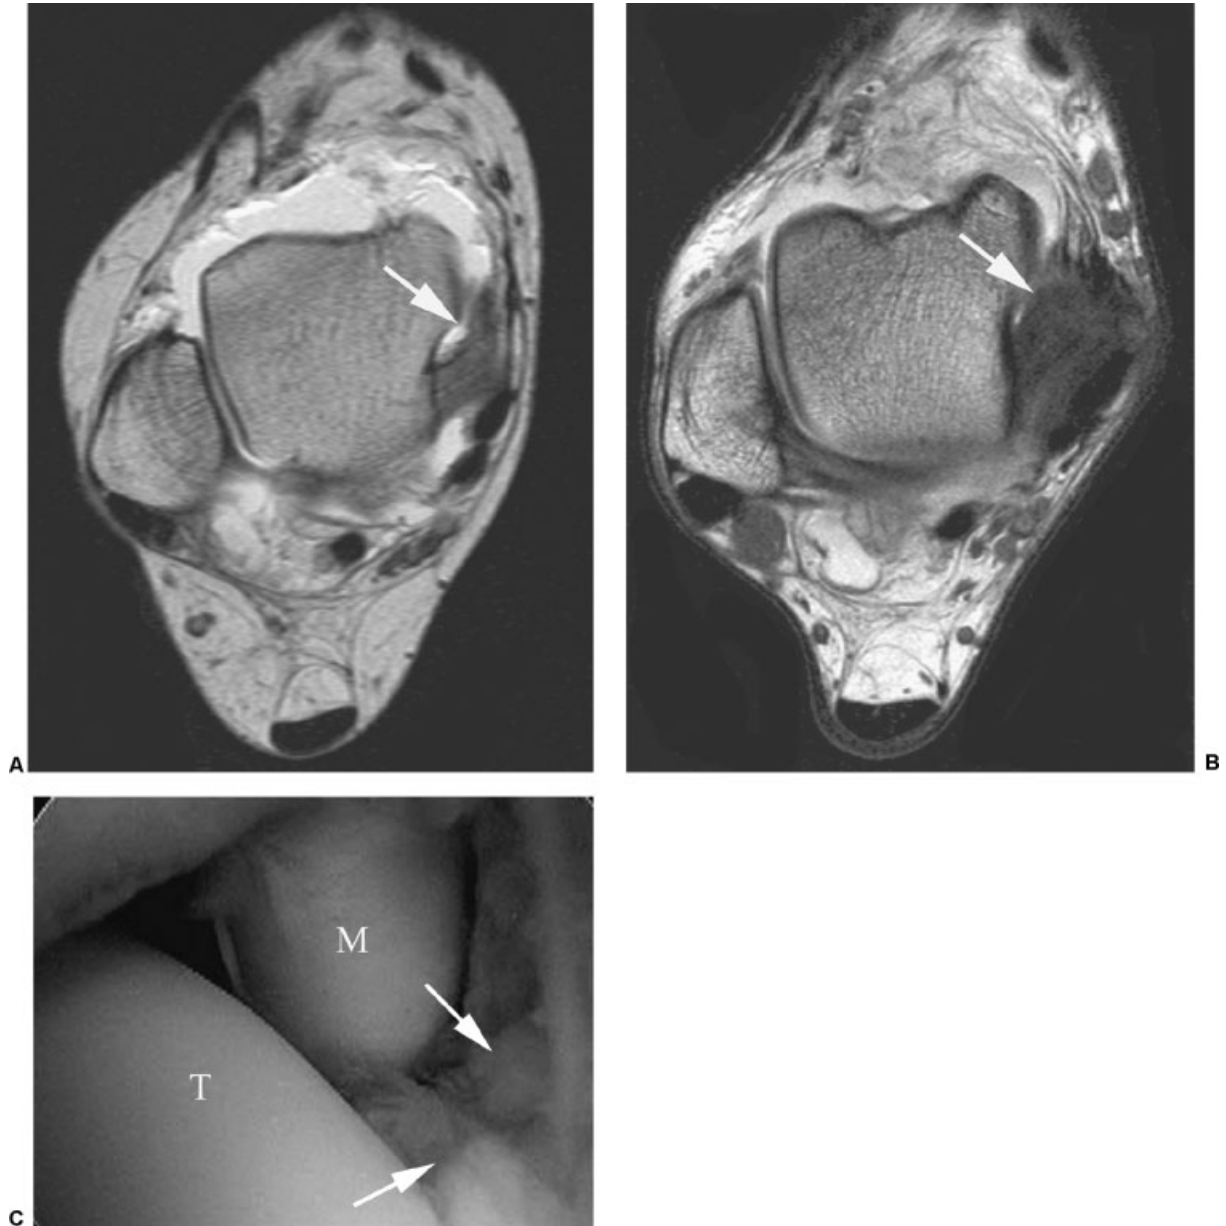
Axial T1-weighted spin-echo magnetic resonance arthrographic images from two different patients demonstrate (A) a normal striated appearance of the deep deltoid ligament on the left (arrow) versus (B) irregular soft tissue thickening in the anteromedial capsular recess and loss of the normal striated appearance of the deep deltoid ligament on the right in a patient with anteromedial impingement syndrome (arrow). (C) Corresponding arthroscopic image demonstrates the anteromedial impingement lesion (arrows). M, medial malleolus; T, talus. Reprinted with permission of Dr. Antonio Cruz, Santander, Spain.
